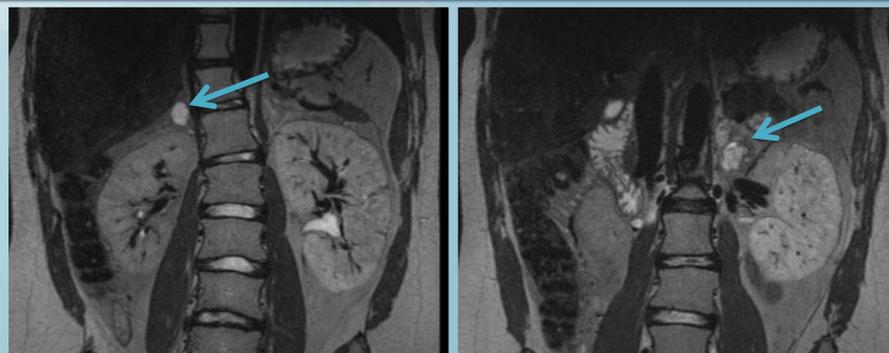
and 1B. MRI 3D T2 images showing complex adrenal cysts bilaterally
